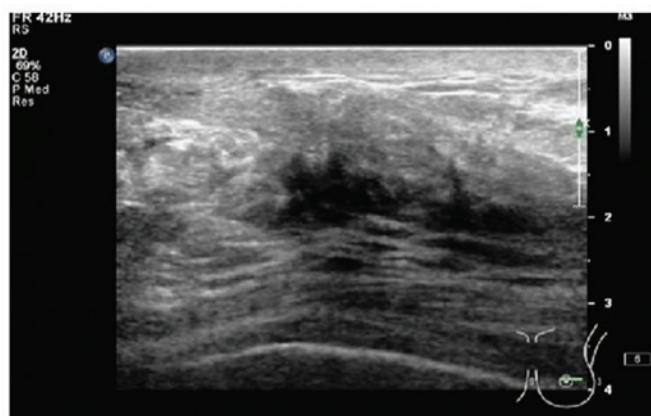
Ultrasonography of the breast revealing a solid heterogeneous mass in the breast, suspected to be a malignant tumor, with edema and thickening of the subcutaneous soft tissue on the left areola.
